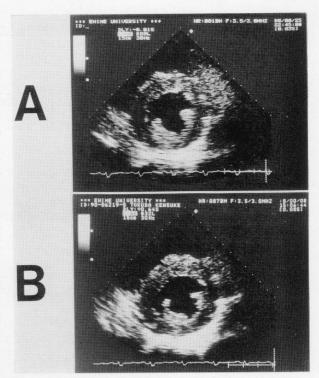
Two-dimensional echocardiograms of the patient, (A) on admission and (B) after 3 months of the admission. Both echocardiograms almost unchanged.
